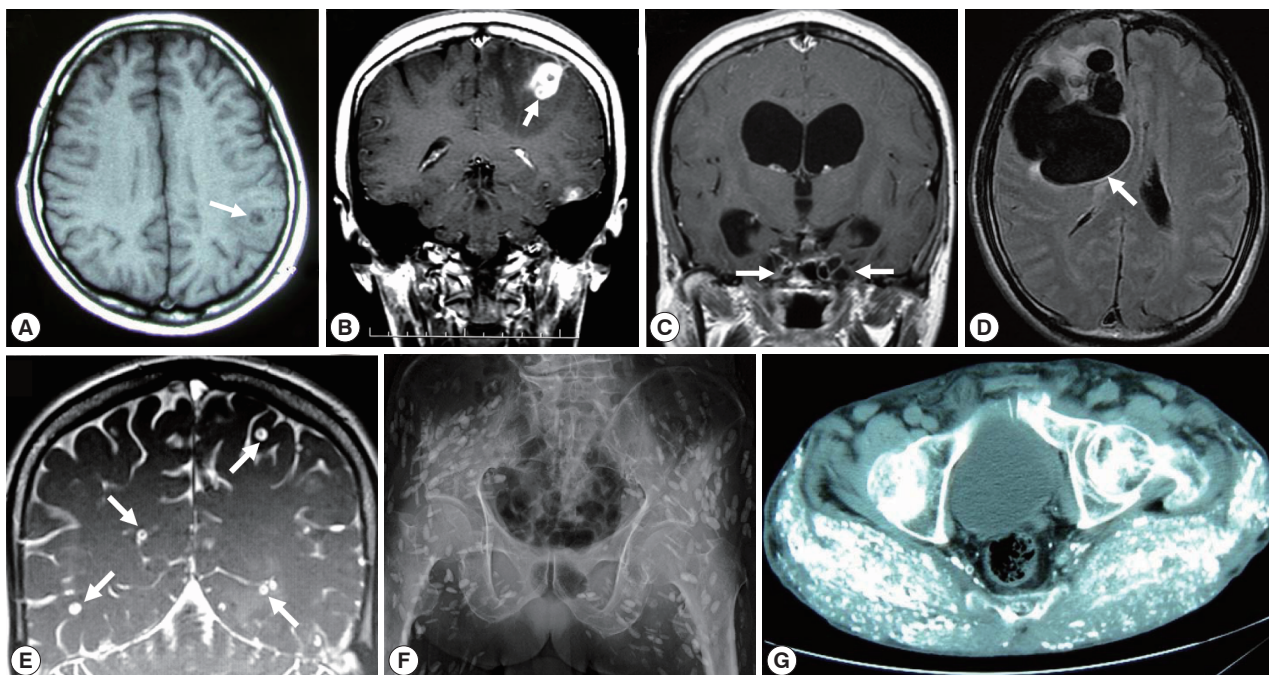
Imaging findings of selected cysticercosis cases. (A) plain CT image showing a solitary lesion at the left occipitoparietal area (case 48 [32], courtesy of Prof. H. Matsuoka). (B) MRI showing one of multiple cystic lesions in the left frontal and temporal lobes (case 49 [33]). (C) MRI showing a racemose-type lesion at the basal cistern (case 50 [34], courtesy of Dr. T. Oda). (D) MRI FLAIR findings showing a giant and multilobulated mass in the subarachnoid spaces of the right frontal lobe (case 62 [40], courtesy of Dr. S. Shiiki). (E) Cisternography showing multiple cysts in the brain (case 60, courtesy of Prof. A. Chiba). (F) X-ray findings showing typical rice grain calcifications in the muscles of buttocks and lower extremity (case 44 [27, 28], courtesy of Dr. T. Nagase). (G) CT findings showing numerous calcified cysts in muscles of the of the buttocks (case 52 [36], courtesy of Dr. M. Tsuda).
